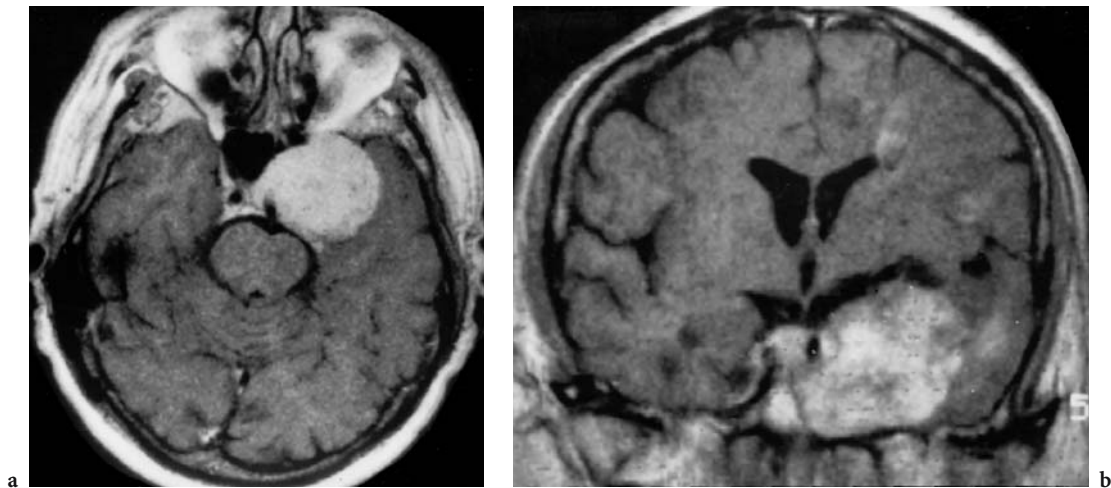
A 50-year-old man with left N VI paresis. Diagnosis: cavernous hemangioma. MRI: a Axial T1-weighted native view showing a huge, hyperintense, extra-axial, well-defined formation originating in the lateral region of the cavernous sinus. Note compression of the temporal parenchyma and the brainstem, as well as the sharply defined depression of the sphenoid sinus. b Coronal T1-weighted native view with distinct visualization of the expansion into the cavernous sinus and the clivus. (With permission of Drs Kemmer and Grebe, DKD, Wiesbaden)
